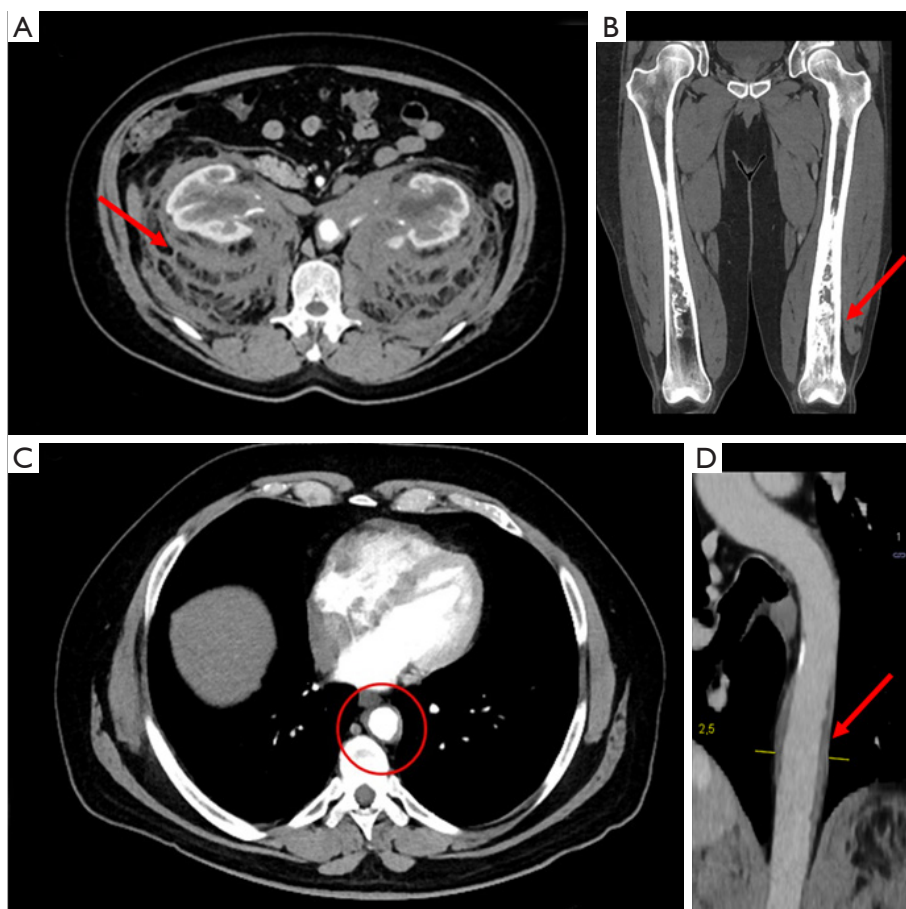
Dual source computed tomography (DSCT) findings in Erdheim-Chester disease (ECD). (A) Axial CT scan showing *hairy kidney sign* (red arrow); (B) Coronal CT multiplanar reconstruction showing an asymmetric sclerotic lesion of both the femurs (red arrow); (C) Axial view of thoracic DSCT displaying the “*coated aorta sign*” (red circle); (D) Curved Multiplanar Reconstruction (c-MPR) of thoracic aorta with wall concentric thickening (red arrow).
